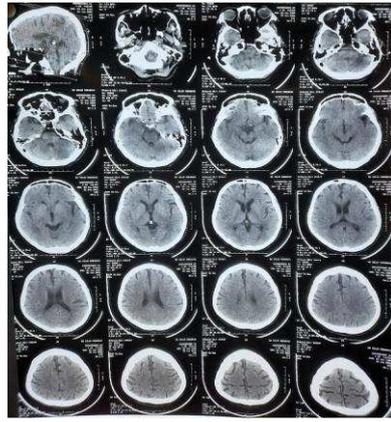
CT Scan Examination on Patient during Hospital Admission
